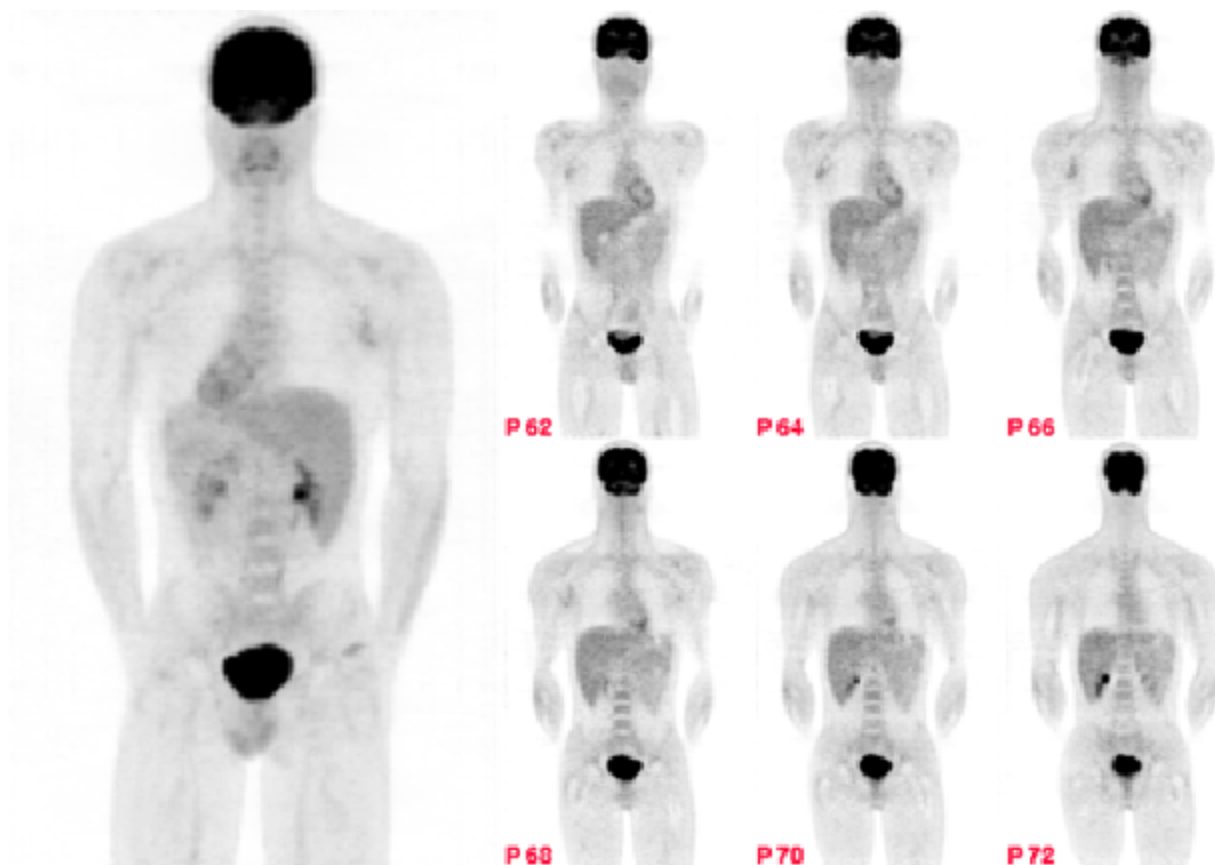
Image of a 25 year old, 71 kg, male melanoma patient 45 min post injection of 16 mCi FDG, 9 bed positions acquired for 3 min emission and 2 min transmission each.
